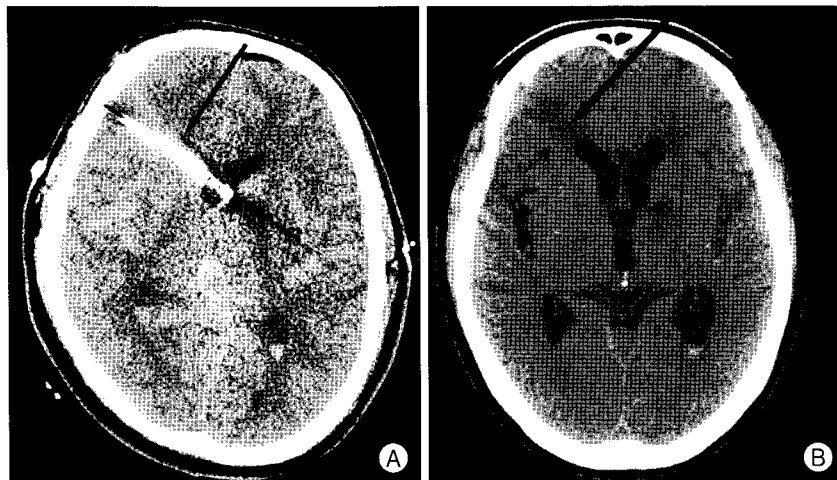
Brain axial computed tomographic scans showing hyperdense areas (arrow) around the ventriculostomy catheter (A) and hypodense areas (arrow) along the catheter trajectory (B).
